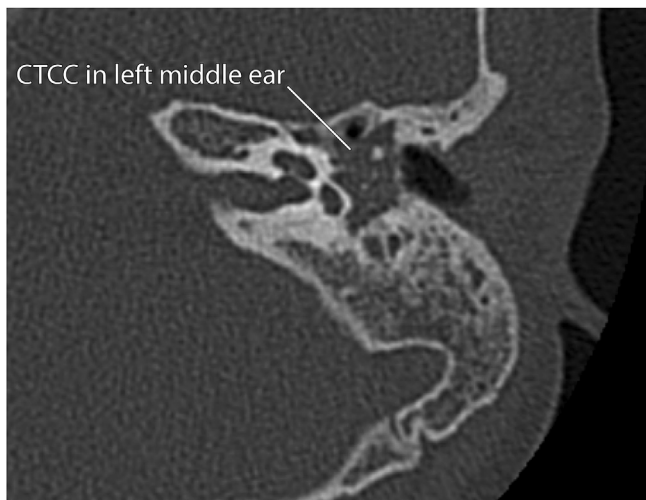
Axial CT image of a left CTCC in a 5-year-old.
